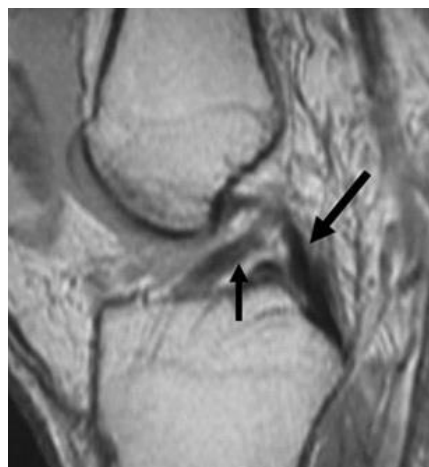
Sagittal MRI image shows a chronic tear in the anterior cruciate ligament. ACL appears retracted and angular (thin arrow), and normal PCL (thick arrow).
